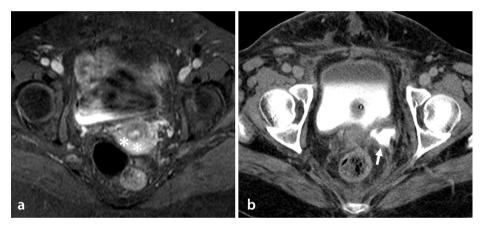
A 55-year-old woman with cervical carcinoma. Axial post-contrast fat-saturated T1 weighted magnetic resonance image shows carcinoma of the posterior cervical wall (a, asterisk). Post-surgical abdominal CT urography demonstrated distal ureteral contrast extravasation (b, arrow). CT, computed tomography.
